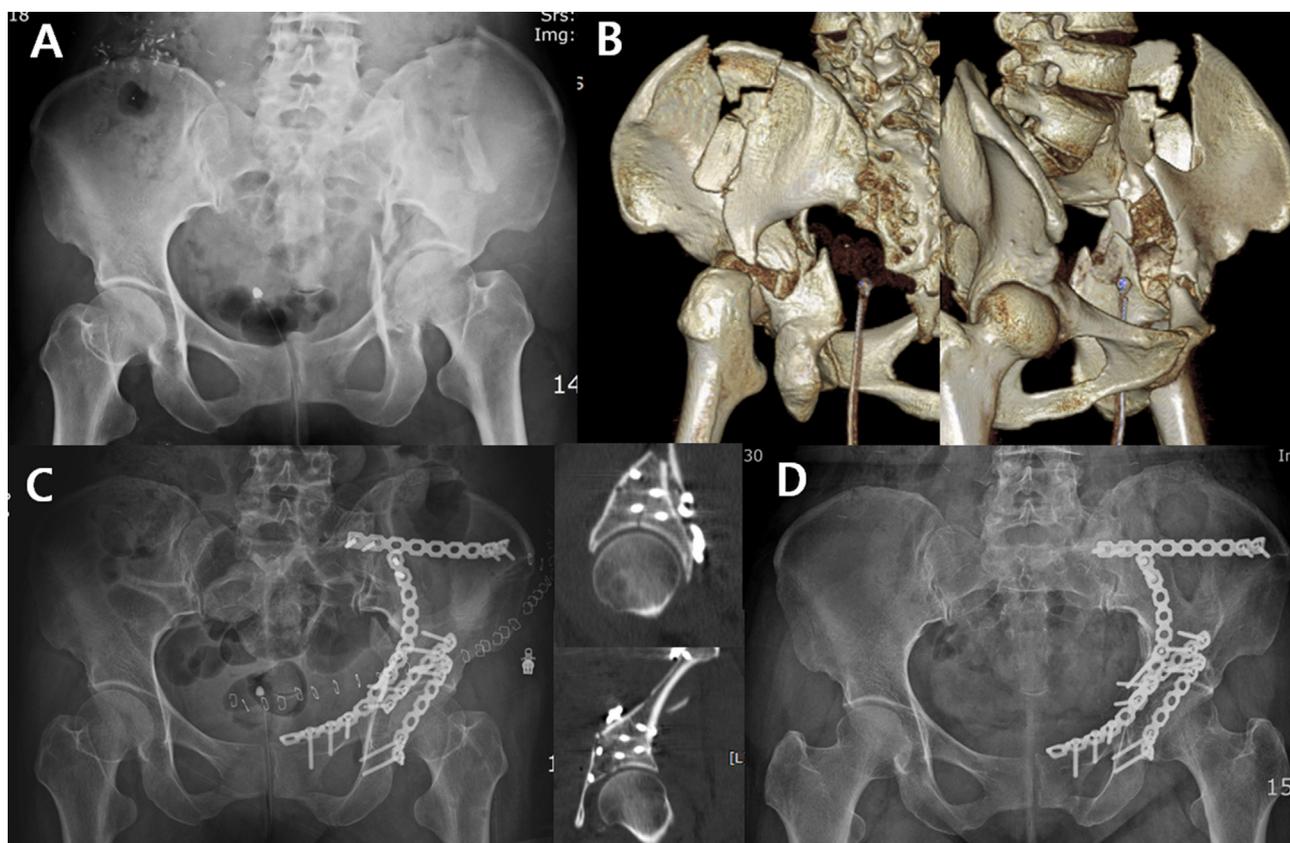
(A). Pelvis anteroposterior radiograph and (B) 3-dimensional (3-D) CT of a 54-year-old female, showing an anteromedially displaced both-column fracture with a posterior wall component. (C). Postoperative anteroposterior radiograph and CTs after anterior fixation through the modified ilioinguinal approach and staged posterior fixation through Kocher-Langenbeck approach. (D). Final pelvis anteroposterior radiograph 48 months after surgery.
